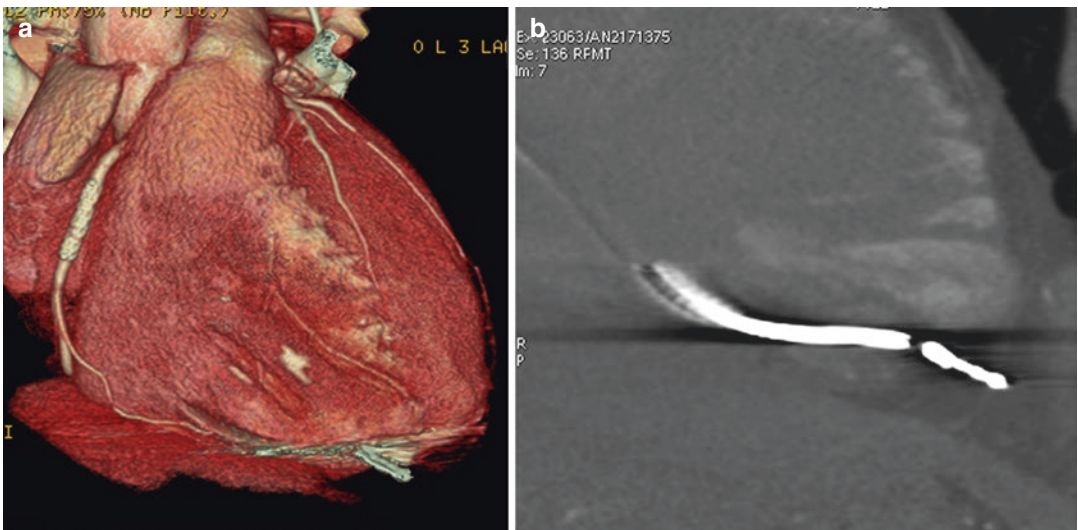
Myocardial laceration caused by cardiac catheter. Gated cardiac CT acquisition. (a) VRT reconstruction shows the catheter end that goes beyond the myocardial wall. (b) MIP reconstruction
